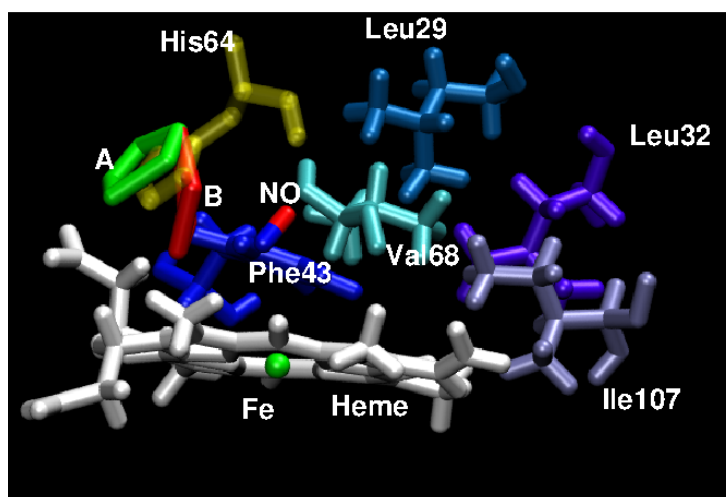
States A (green) and B (red) as found from the per-atom pdfs of the His64-side chain atoms. In gold the X-ray reference structure.
